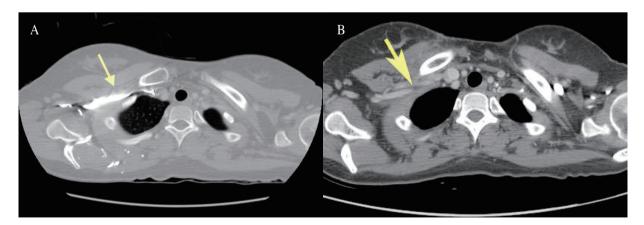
(A) Preoperative chest computed tomography (CT) scan reveals compression of the right subclavian artery and vein between the clavicle and first rib (arrow). (B) Post operative chest CT scan reveals decompression of the right subclavian artery and vein between the clavicle and second rib in one year after the first rib resection.
